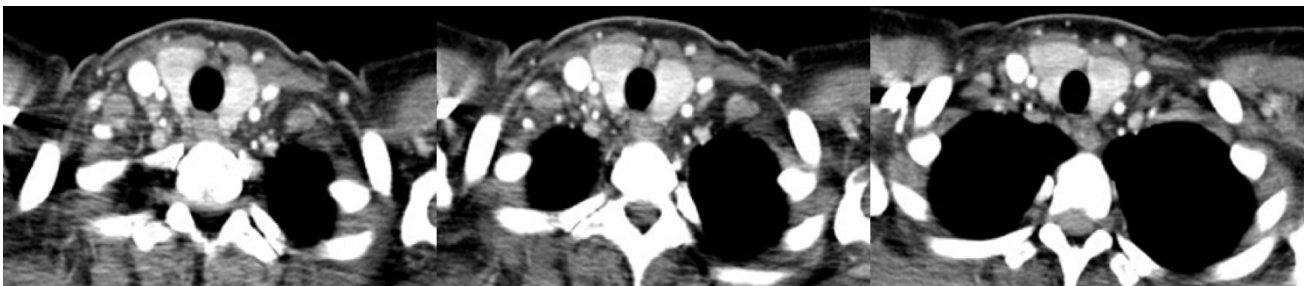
Thyroid on enhanced CT. There were no nodules within the thyroid.
